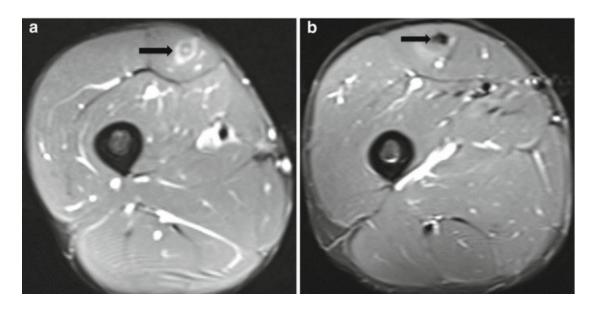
A 22-year-old male athlete with a central injury of the deep myotendinous junction. Axial fat-suppressed T2-weighted MRI (a) at initial presentation and (b) 12 months later. (a) High-signal ring around the deep tendon with bull's eye appearance consistent with central injury (arrow). (b) Twelve months later, fibrous encasement appears as low-signal thickening of the deep tendon (arrow)
